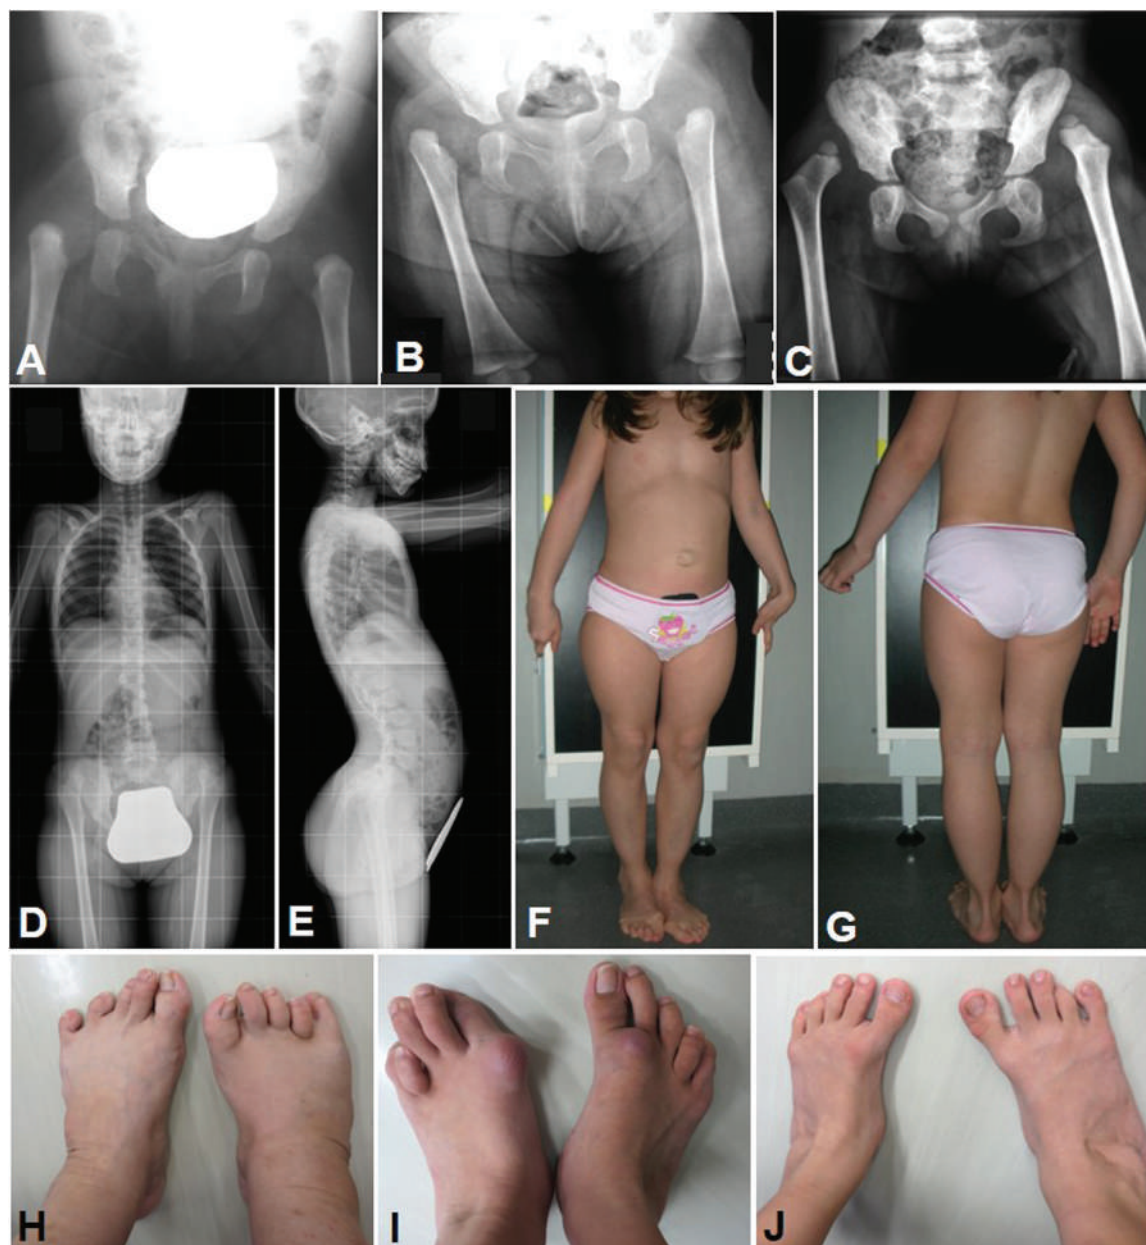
Clinical photographs and radiological images of patients with aEDS. A girl (A–G) with a $c.279+1G>$ mutation in *COL1A2* and a mother and her two sons (H–J) with a $c.279+2T>C$ in *COL1A2*. (A) X-rays of the hip at age 7 days showing congenital bilateral hip dislocation and femoral and acetabular deformities. (B and C) Status of the hip dislocation at age 5 months and 3 years, respectively. (D) An anteroposterior total body radiograph at age 11 years showing unsuccessful treatment of the hip dislocation with harness and bracing. (E) A left lateral total body radiograph at age 11 years showing lumbar lordosis. (F and G) The patient at age 9 years with umbilical hernia, lordotic posture of the spine, and foot deformities. Foot deformities of an affected mother at age 38 years (H), her first son at age 14 years (I), and her second son at age 5 years (J) (Images A–G kindly provided by Prof. Maria Luisa Giovannucci-Uzielli, with permission).
